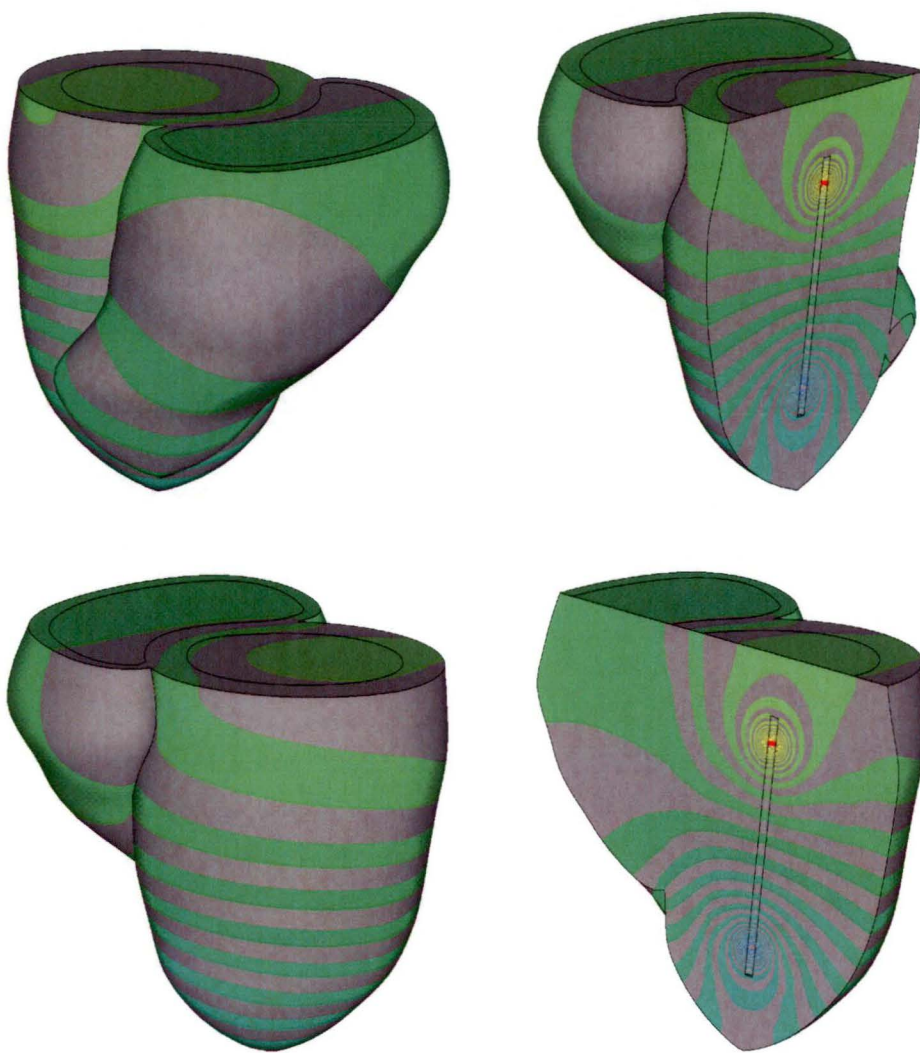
Left ventricle catheter voltage contours in tagged MRI model at end diastole for blood conductivity/myocardium conductivity = 2.75.
